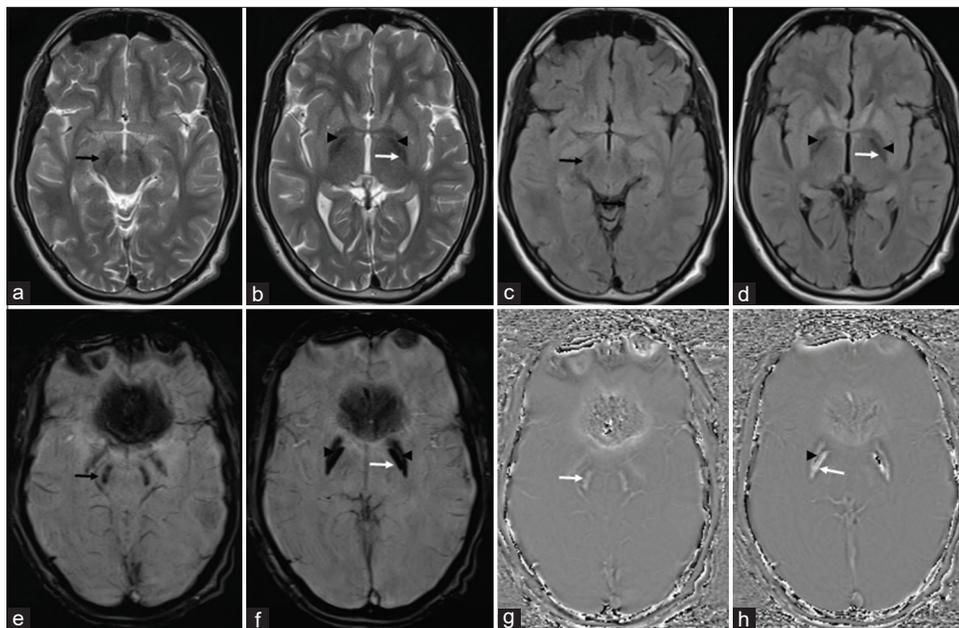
Magnetic resonance imaging of the brain. T2-weighted (a, b) and FLAIR (c, d) axial images showing symmetrical hypointense signal changes in the bilateral substantia nigra (a, c; black arrow) and globus pallidum (b, d; white arrow) with a linear hyperintense streak in the medial medullary lamina, between the globus pallidi internus and globus pallidi externus (b, d; arrowhead). These images also demonstrate bilateral and symmetrical hyperintense signal changes in caudate and putamen. Susceptibility-weighted (e, f) axial sequences show bilateral hypointense signal changes in the substantia nigra (black arrow) and globus pallidus (white arrow) with a hyperintense streak in the medial medullary lamina (arrowhead). These signals are hyperintense (g, h; white arrow) on filtered phase sequences with a medial streak of hypointense signal changes (h; arrowhead)
